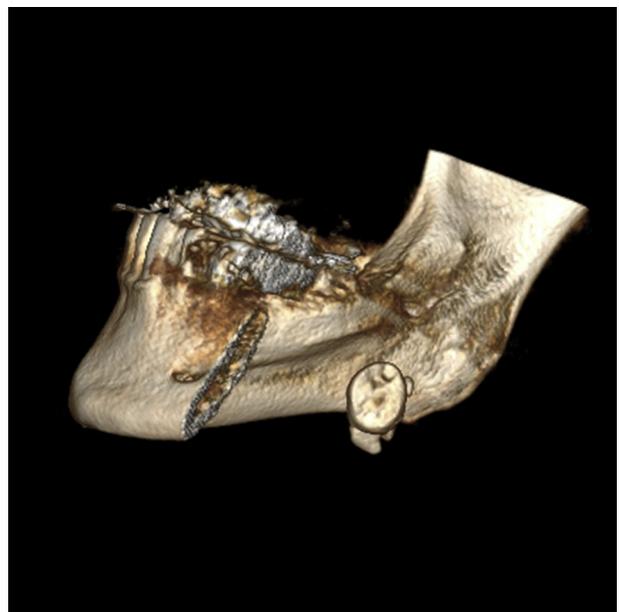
Patient 2. Cone-beam computed tomography image, 3-dimensional view of the medial aspect of the right mandible.
